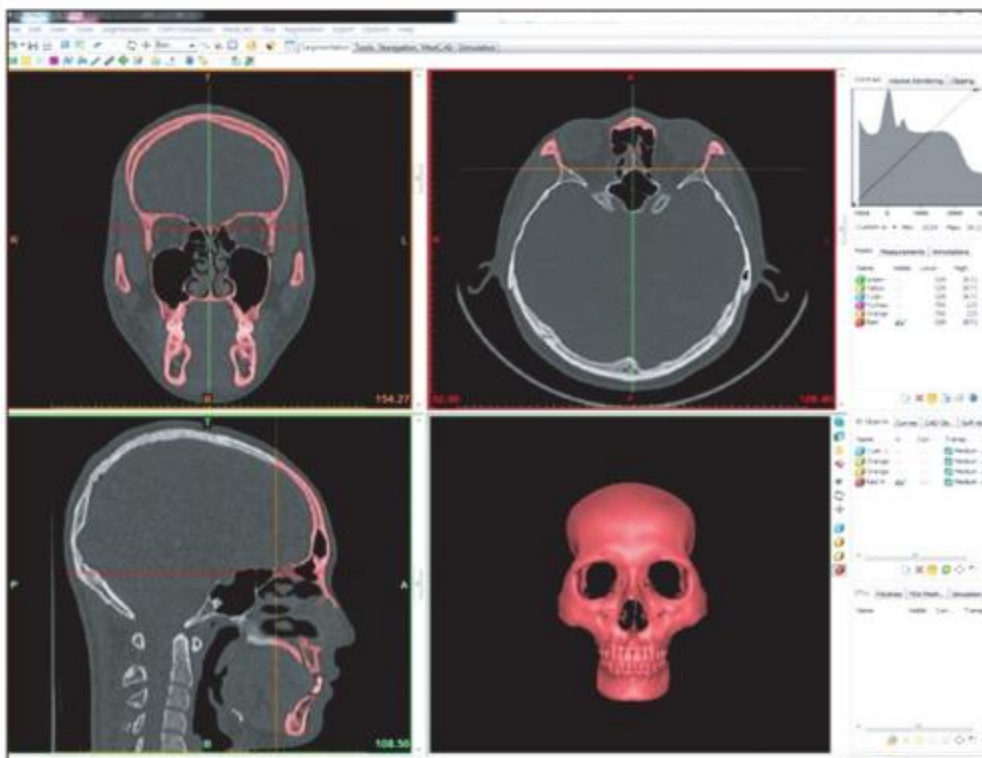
Method used for the three-dimensional computed tomography-image reconstruction [37]
